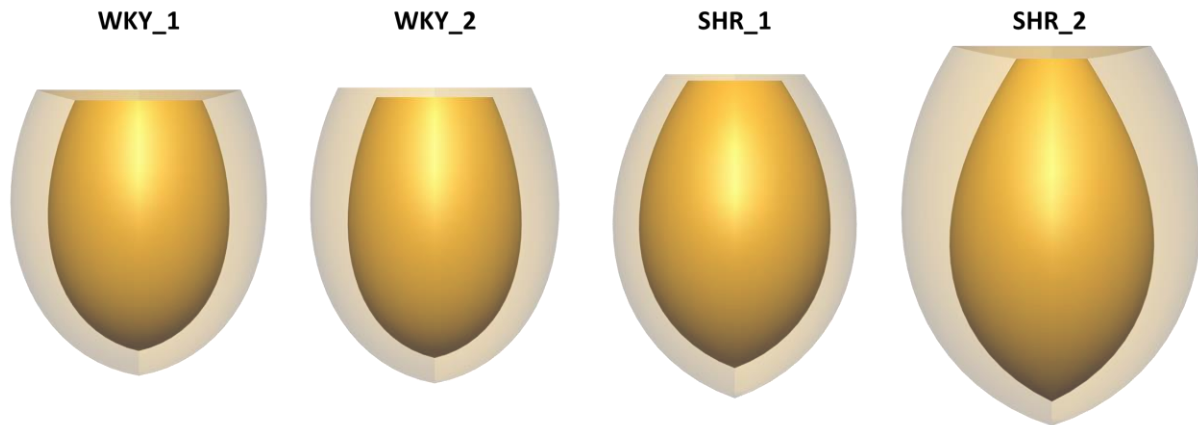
3D LV FE models customised to *in vivo* MRI of two WKY and two SHR hearts at diastasis.
